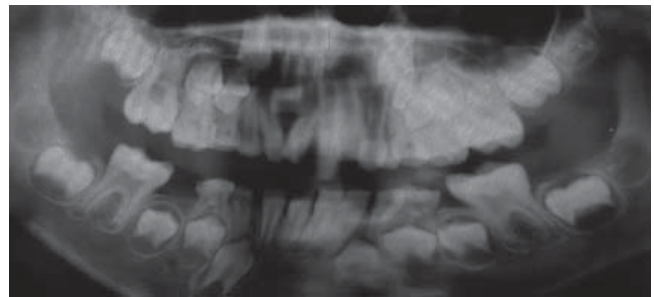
Panoramic radiograph. Presence of three supernumerary teeth in the upper anterior region.
